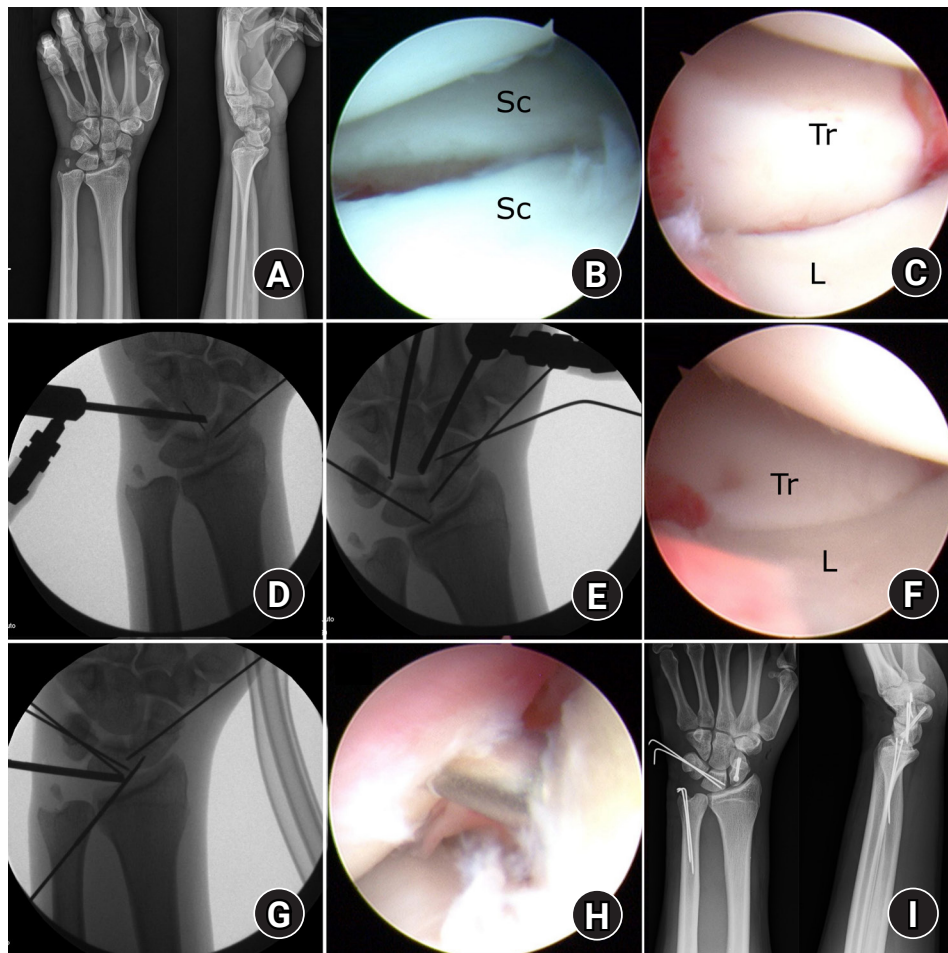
Arthroscopic-assisted reduction and fixation for a trans-scaploid perilunate fracture dislocation (PLFD). (A) Posteroanterior (PA) and lateral views of the preoperative radiographs of a 21-year-old male showing a dorsal trans-scaploid PLFD of the left wrist. (B, C) An arthroscopic photo viewed from the ulnar midcarpal portal, showing a scaphoid fracture and instability of the lunotriquetral joint. (D) The scaphoid fracture was reduced with manipulation of the distal fragment using an 18-gauge needle. Then a Kirschner wire was inserted from the scaphoid tubercle and passed through the fracture site for temporary fixation. (E) The lunotriquetral joint was reduced using a probe and percutaneously pinned from the ulnar side of the wrist. (F) The lunotriquetral joint was well reduced after pinning. (G, H) The optimal starting point for screw fixation of the scaphoid is targeted using the arthroscope and fluoroscope. (I) The postoperative PA and lateral views showing proper fixation and normal carpal alignment. L, lunate; Sc, scaphoid; Tr, triquetrum.
